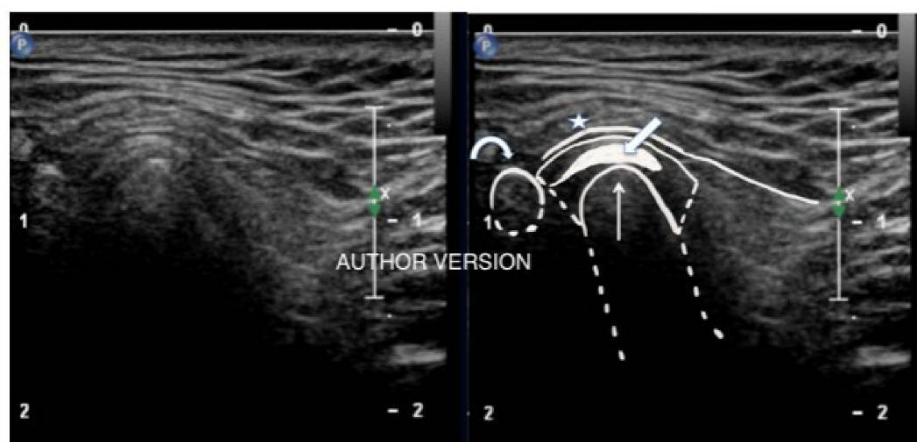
Ultrasound in TMJ Assessment
